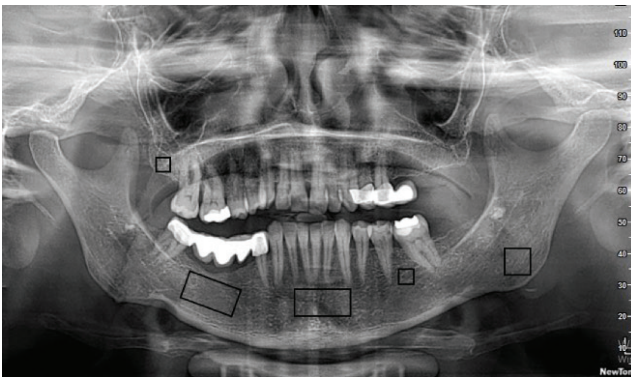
ROIs were selected for fractal analysis on panoramic radiography
